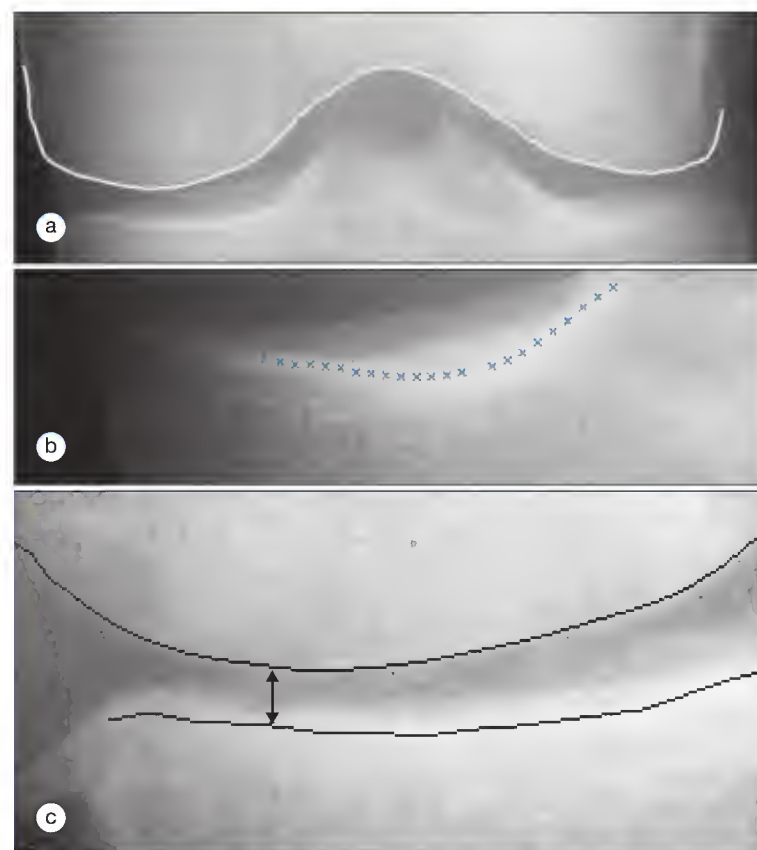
Computerized x-ray image analysis for joint space narrowing. (a) Computer-delineated femoral condyle shown as the white line overlaid on the knee radiograph. (b) Computer-determined joints along the bright band corresponding to the base of the tibial plateau. (c) Computerized determination of minimum joint space width. The points on the tibial plateau have been connected. The shortest distance between the femoral condyle and the tibial plateau is automatically detected.
